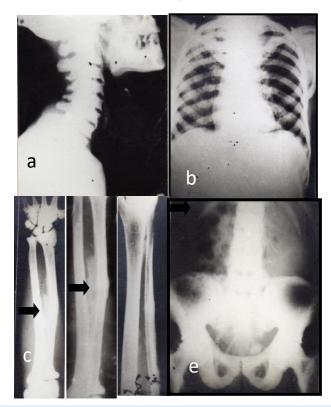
Radiographs of different bones of subjects, afflicted with skeletal fluorosis. Cervical and dorsal spines showing extreme osteosclerosis, lipping and osteophytosis (a, e); osteosclerosis of the pelvis with calcification of ligaments (e); contrast of the osteosclerosis in bony cage with radiolucent lungs and clavicular involvement (b); calcification of interosseous membrane (arrow) between radius and ulna bones of forearm (c); bony exostosis in tibia (d). The calcification of interosseous membrane (arrow) is the most ideal and confirmative indication of skeletal fluorosis.
